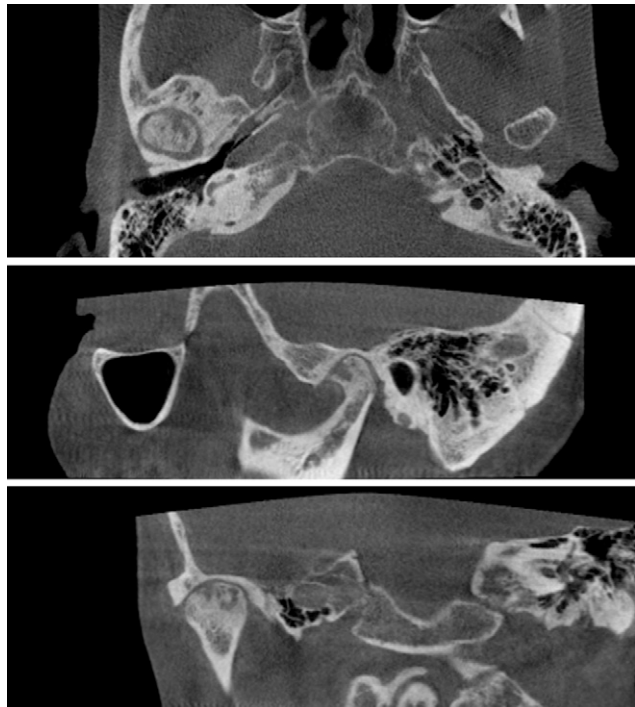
CBCT of rheumatoid arthritis: punched-out destruction with sclerosis (female, 59 years).
